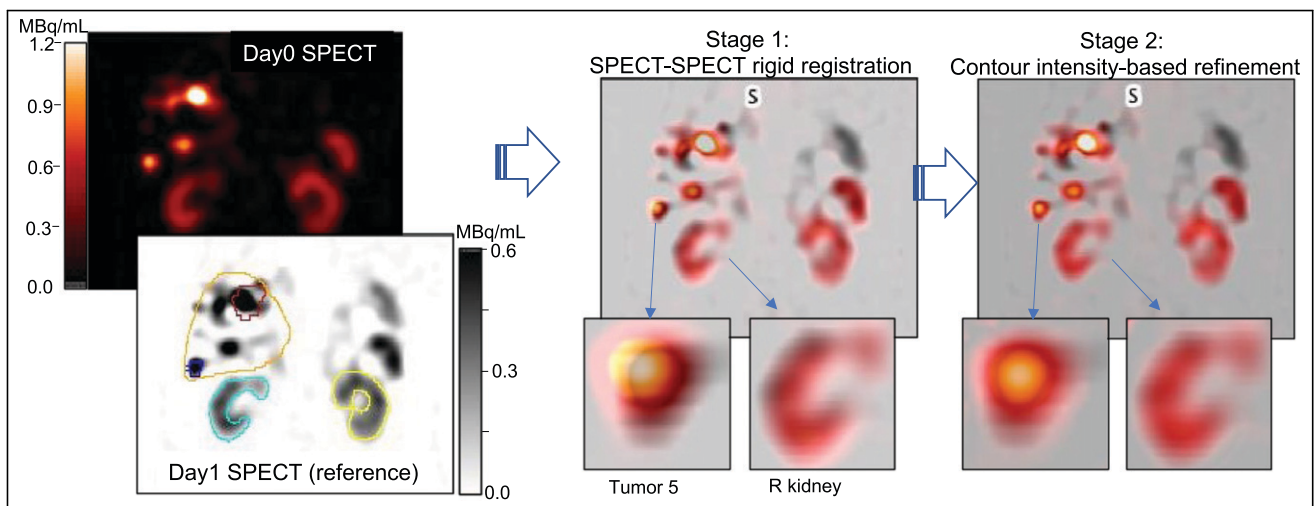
Two stages of automatic SPECT–SPECT registration demonstrated for day 0 and day 1 images of patient 12. Comparison of magnified inserts shows subtle improvement in alignment with contour intensity-based refinement.
